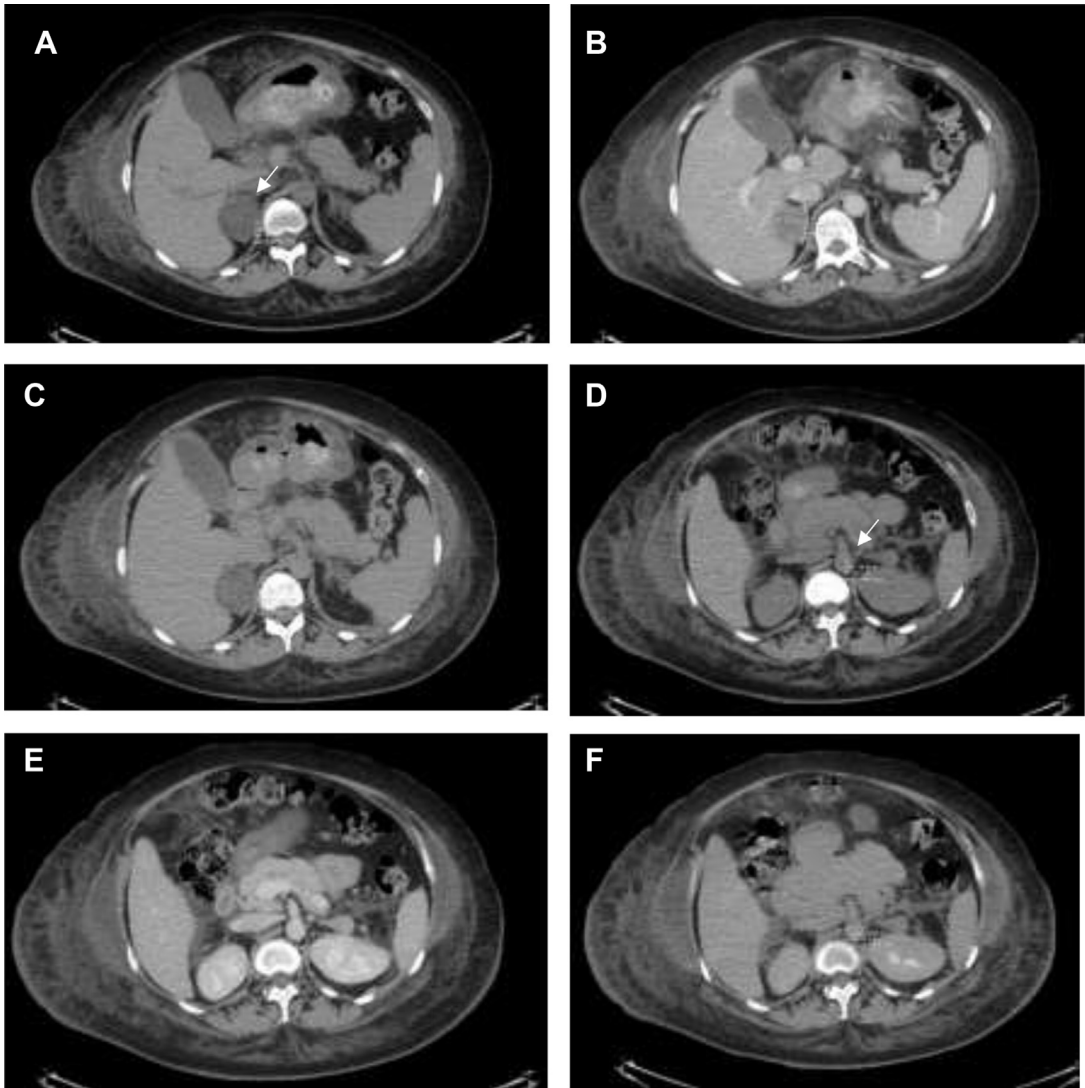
A 28-year-old woman presented to the endocrinology clinic with recently diagnosed hypertension and elevated levels of testosterone during the second trimester of her pregnancy. An MR imaging from another center showed bilateral adrenal masses. Axial unenhanced CT after delivery (A) demonstrates a well-circumscribed oval mass measuring 4 cm involving the right adrenal gland (arrow) with an attenuation of 5 HU. Contrast-enhanced CT in the portovenous phase (B) shows contrast uptake of the lesion with attenuation of 56 HU. Delayed 15-minute axial CT (C) shows contrast washout with attenuation of 24 HU, yielding an absolute enhancement washout of 63%, characteristic of an adenoma. Axial unenhanced CT (D) demonstrates a well-circumscribed oval mass measuring 1.8 cm (arrow) involving the left adrenal gland with an attenuation of 15 HU. Contrast-enhanced CT in the portovenous phase (E) shows contrast uptake of the lesion with attenuation of 91 HU. Delayed 15-minute axial CT (F) shows contrast washout with attenuation of 40 HU, yielding an absolute enhancement washout of 67%, characteristic of a lipid-poor adenoma.
